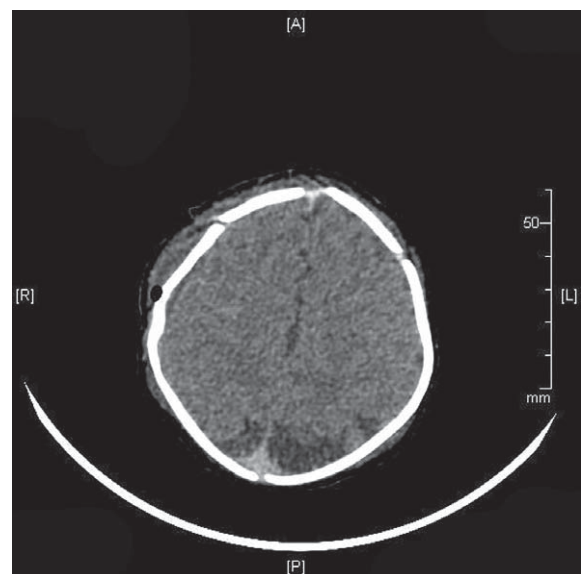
Conventional CT after the operation.
